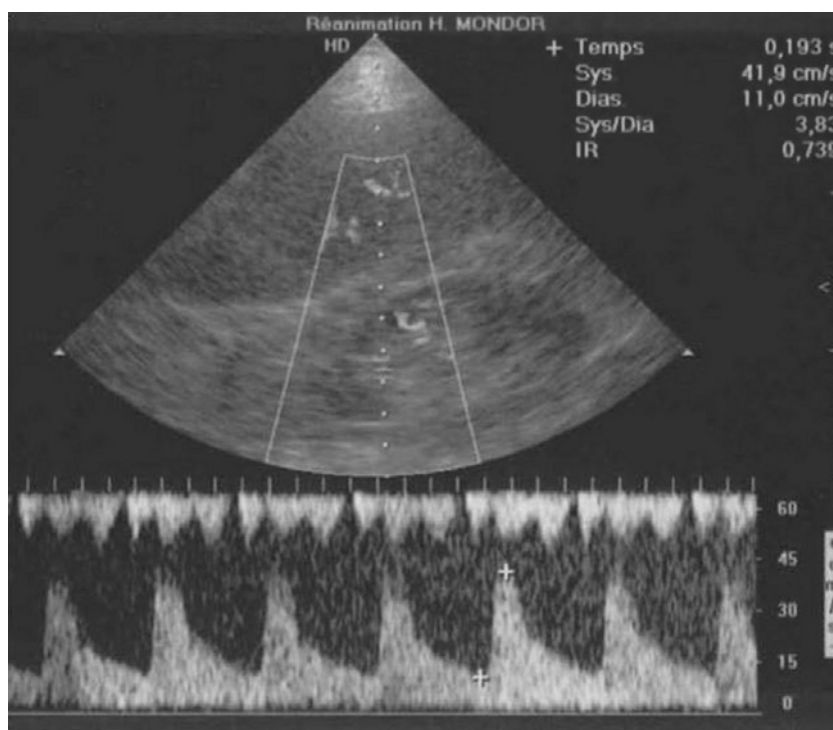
Example of an intrarenal arterial Doppler waveform
